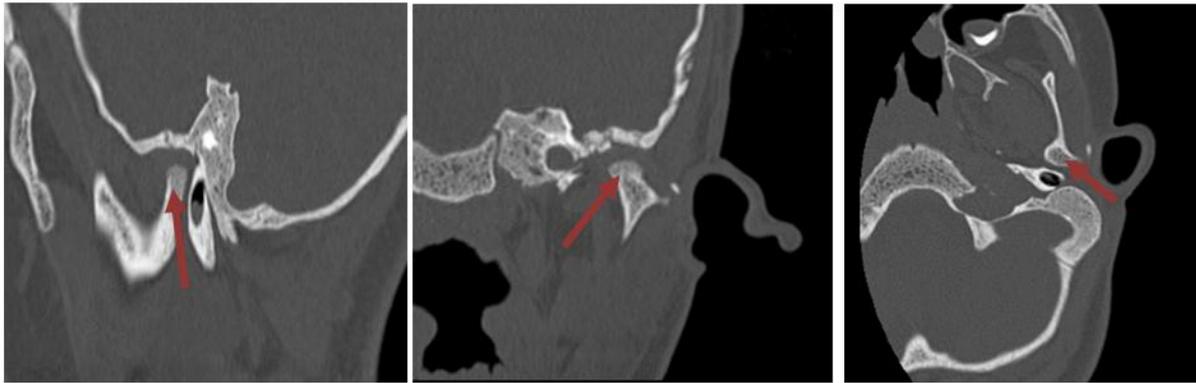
CT sagittal, coronal and axial images showing hypoplastic left mandibular condyle with foreshortened and underdeveloped right mandibular ramus. (→)
